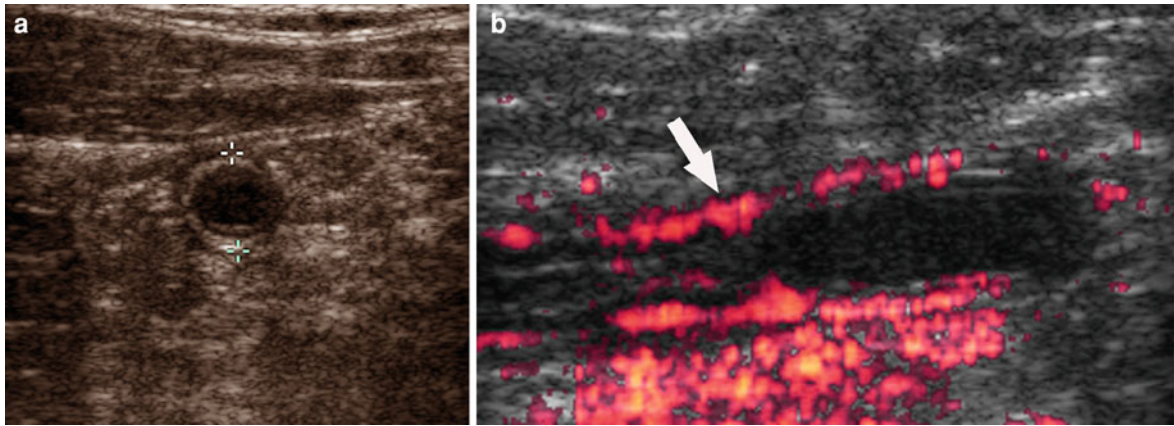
a, b Value of color Doppler sonography in establishing diagnosis of early acute appendicitis. Transverse graded-compression sonogram of short axis of appendix demonstrates
